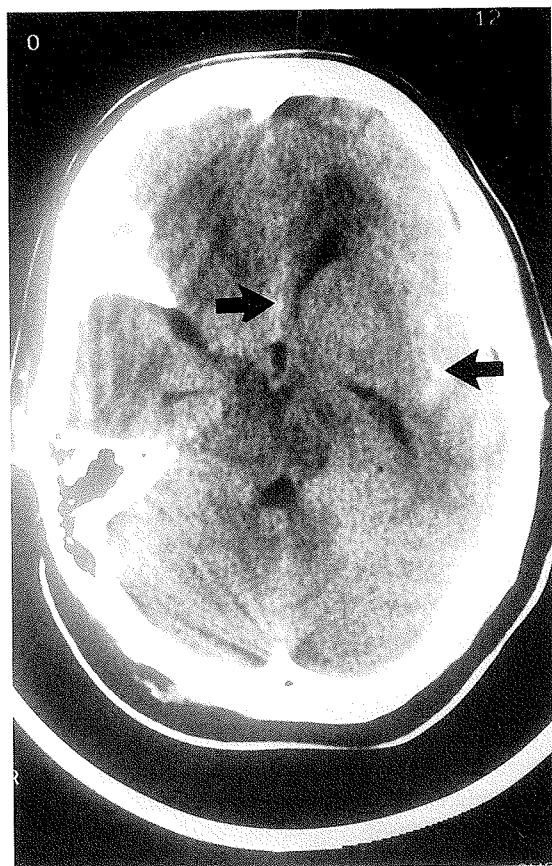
Non-contrast CT scan.
